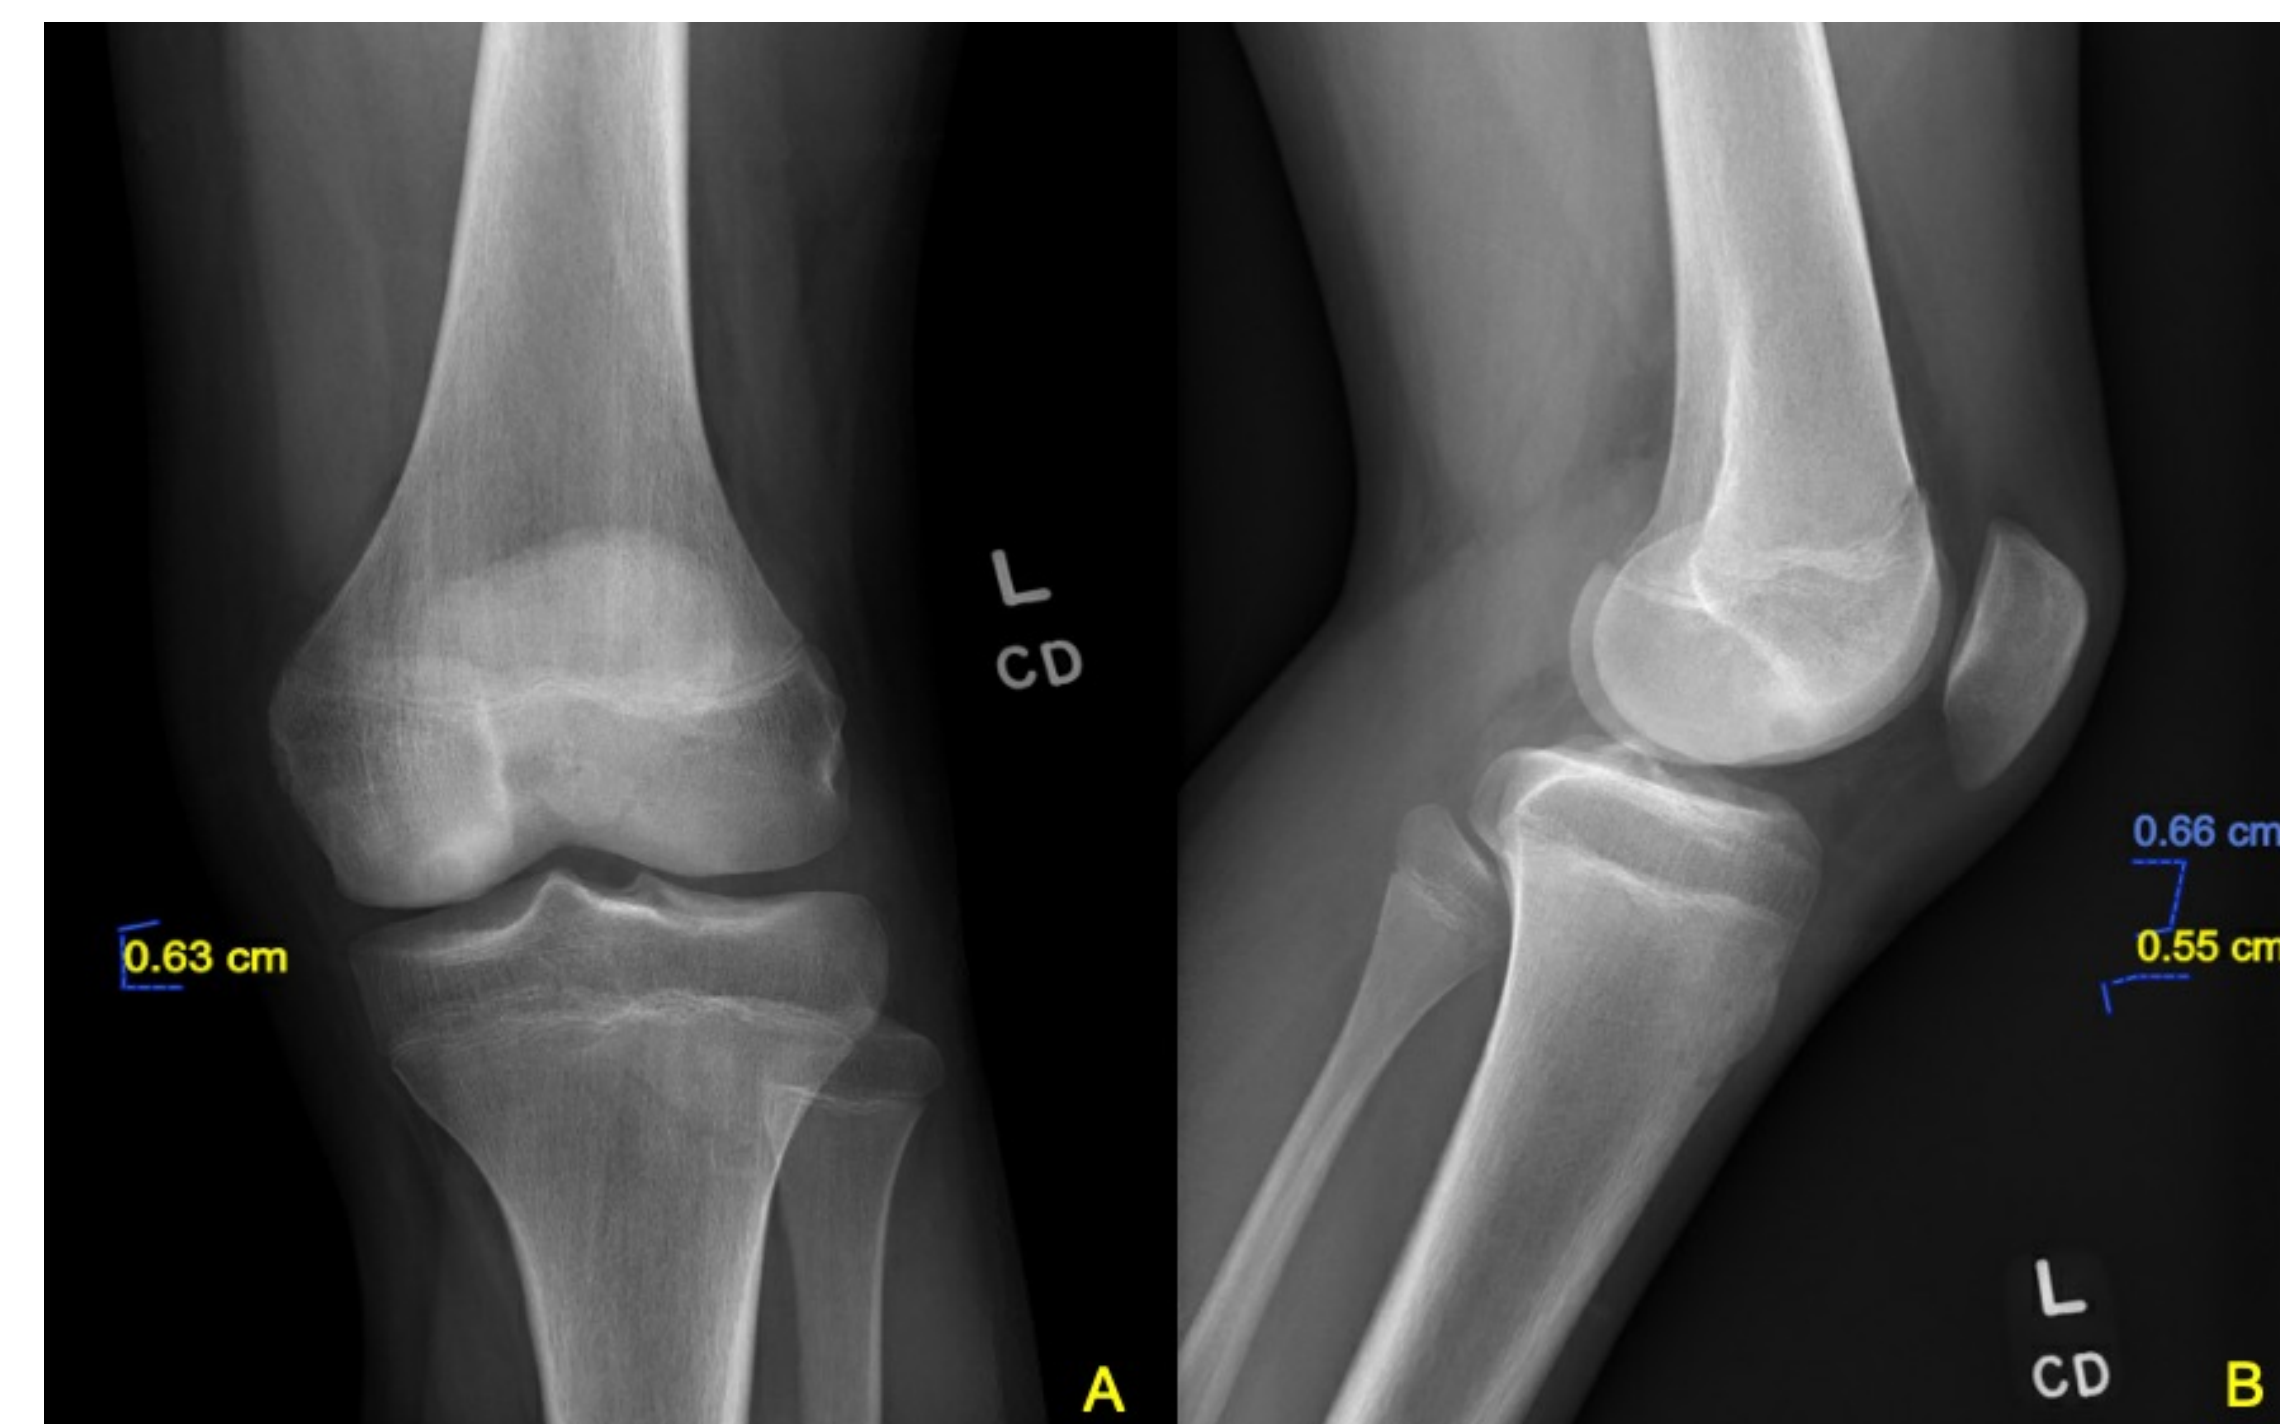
and 1B – Anteroposterior (Fig. 1A) and lateral (Fig. 1B) radiographs of left knee, demonstrating a subchondral round lucent lesion with sclerotic rim in lateral aspect of the medial femoral condyle.
